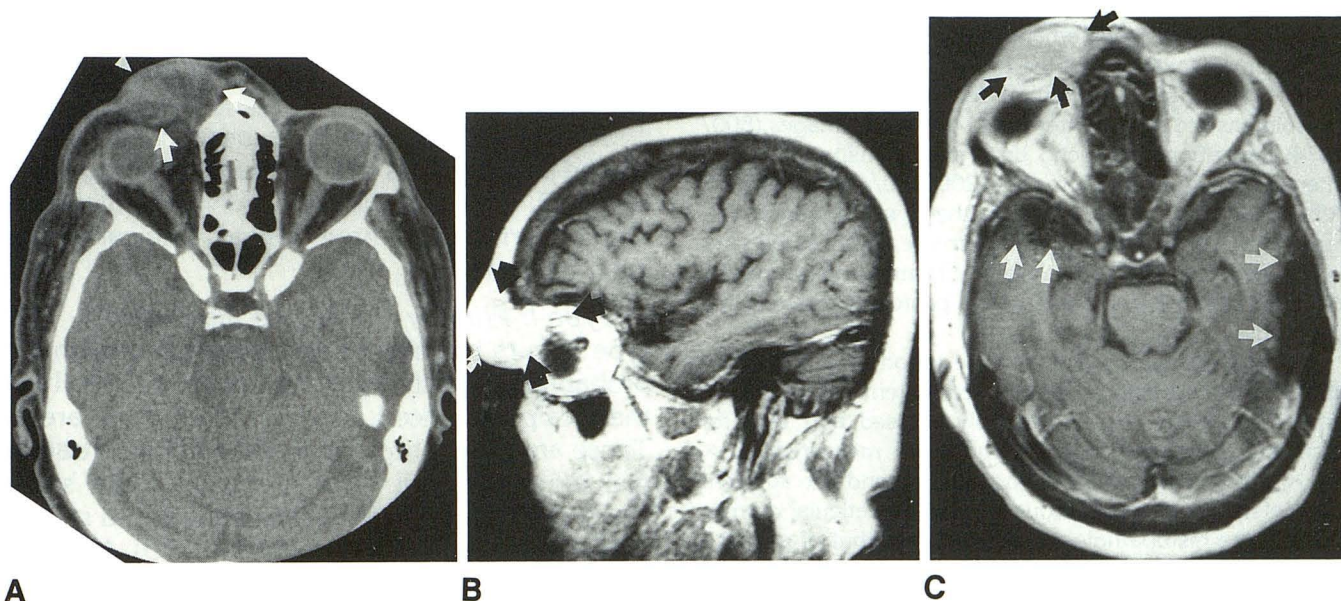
A, Non-contrast-enhanced axial CT image at the mid to upper orbits reveals a heterogeneous 3-cm-diameter right periorbital mass (arrows). The lesion involves the cutaneous and subcutaneous tissues over the medial right orbit and extends into the preseptal fat.
